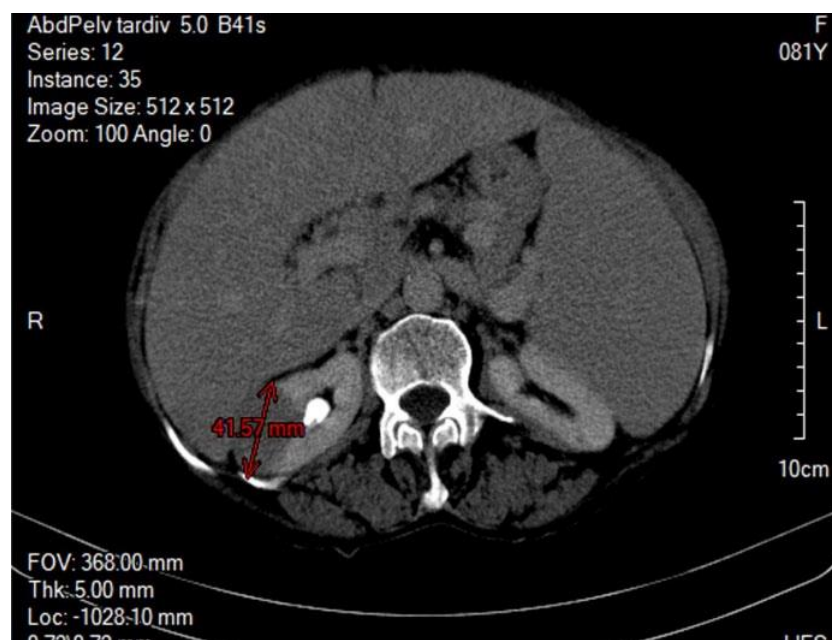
Abdominal CT: right renal tumor of 42/25 mm, splenomegaly of 184/89 mm.
